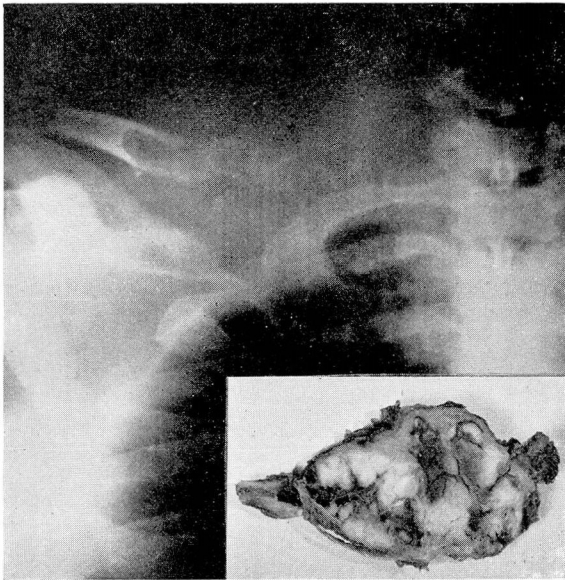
Roentgenogram of right clavicular area.
